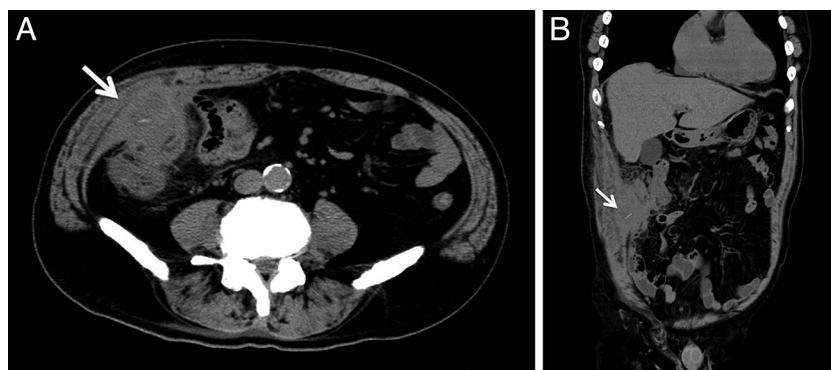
Transverse (A) and coronal (B) sections on computed tomography. The white arrow indicates the intra-abdominal abscess with fish-bone.
